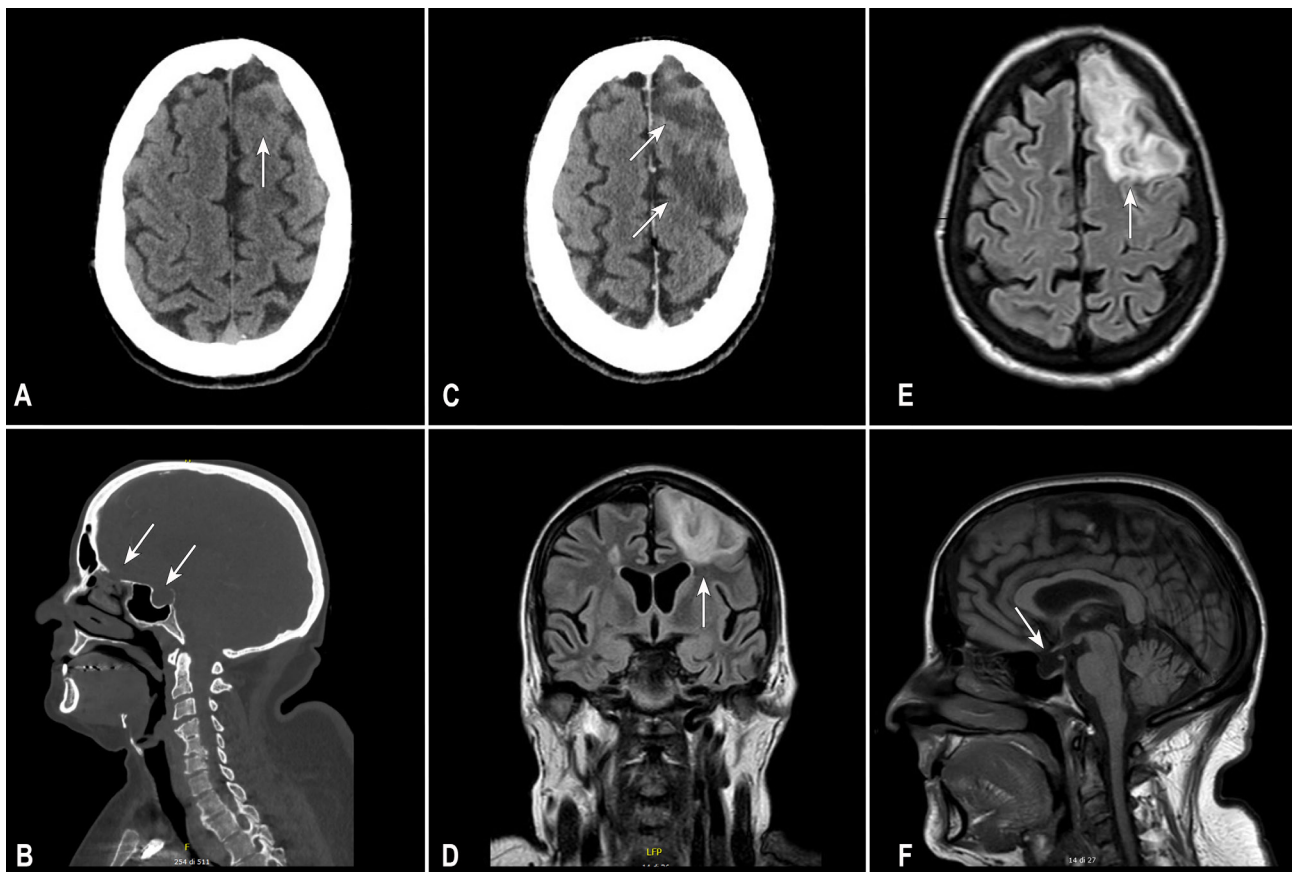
A) Axial CT scan of the brain revealing a small cortical-subcortical hypodensity of the left frontal lobe at admission; B) Sagittal CT scan showing the osteodural defect of the ethmoid roof and enlarged sella turcica at admission; C) Axial contrast-enhanced CT scan after 48 hours showing an increased hypodensity in the left pre-frontal cortex; D-E) 30-day follow-up: coronal and axial fluid-attenuated inversion recovery -weighted magnetic resonance imaging (FLAIR-MRI) confirming the wide hyperintense ischaemic lesion of the left pre-frontal area; F) T1-weighted MRI revealing the sella turcica filled with cerebrospinal fluid.
